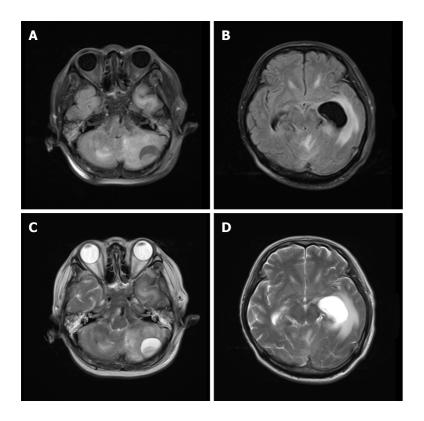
Head magnetic resonance imaging upon admission. A-D: A quasicircular liquid signal opacity was seen in the left cerebellum, with a low T1WI signal (A) and a high T2WI signal (C). The adjacent brain stem was compressed, the fourth ventricle became narrower (A and B), and ventricular hydrops accompanied by paraventricular edema were observed.
